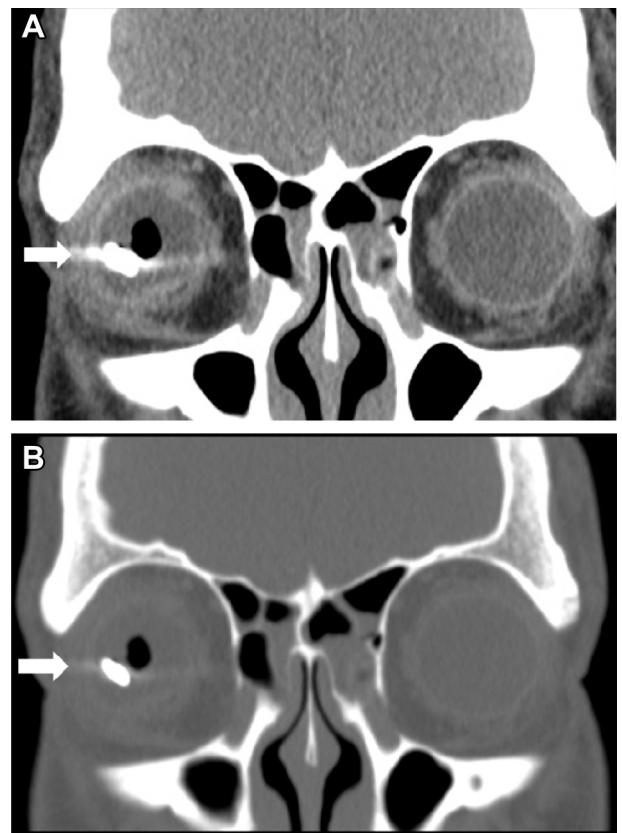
Computed tomography (CT) of Case 13. (A) Original coronal CT shows that a metal foreign body in the right eyeball (arrow) is contributing to blooming artifacts, which is hampering the visualization of the intact sclera wall. It is easy to overestimate that the intraocular foreign body is through the scleral wall. (B) After adjustment of the window level of the CT images with fewer blooming artifacts, coronal view shows that the intraocular foreign body is in the posterior segment of the right eyeball with an intact scleral wall.
